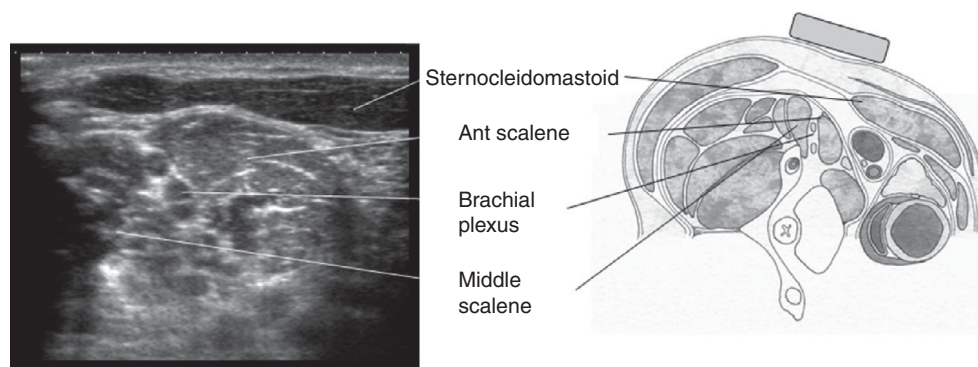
Interscalene anatomy. Reproduced with permission from Arthurs G, Nicholls B (eds.) 2016. *Ultrasound in Anesthesia, Critical Care, and Pain Management*. Cambridge, UK: Cambridge University Press
